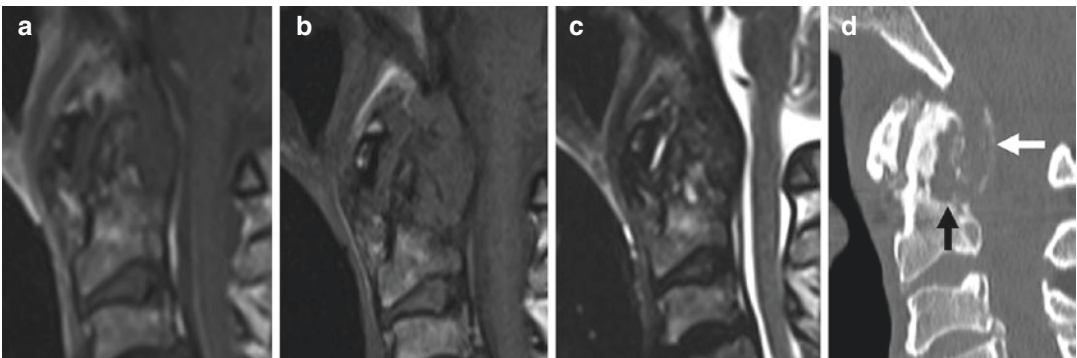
A 62-year-old with CPPD and chronic neck pain. Sagittal T1-weighted, pre- (a) and post-contrast (b), and T2-weighted (c) images demonstrate pronounced erosion/destruction of the C1–C2 articulation and dens with diffuse, low-signal material and very little enhancement.
